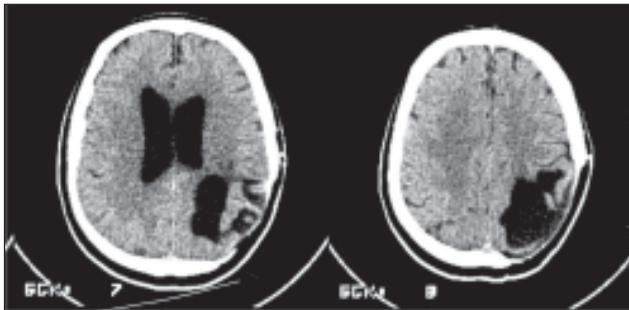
Brain CT from 1998
